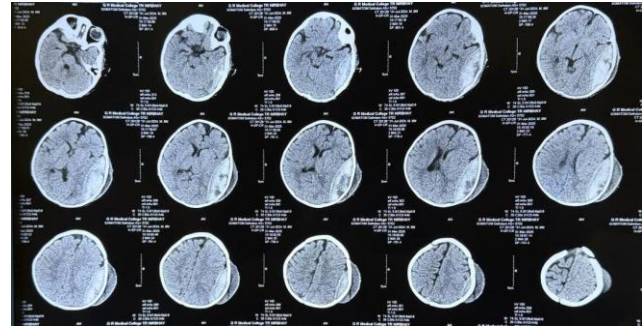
Non-contrast CT head on day 4, showing reduction of the extradural collection to approximately 30 mL.
